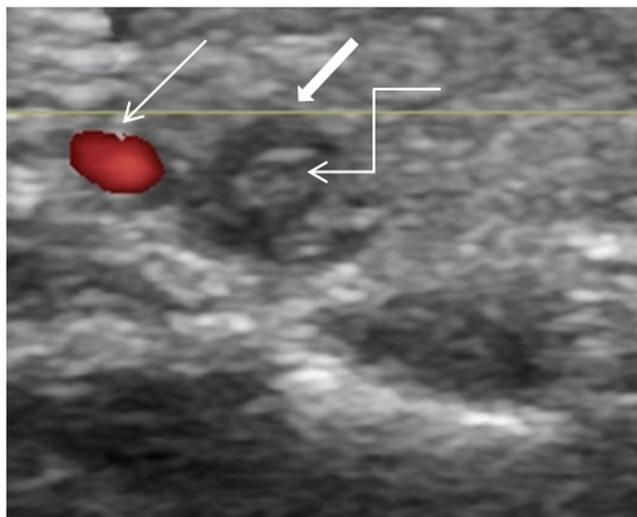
Venous Doppler image showed distended right common femoral vein (thick white arrow) with intra-luminal echogenic content suggestive of thrombus (curved white arrow) and normal right common femoral artery (thin white arrow) confirming ilio-femoral venous thrombosis
